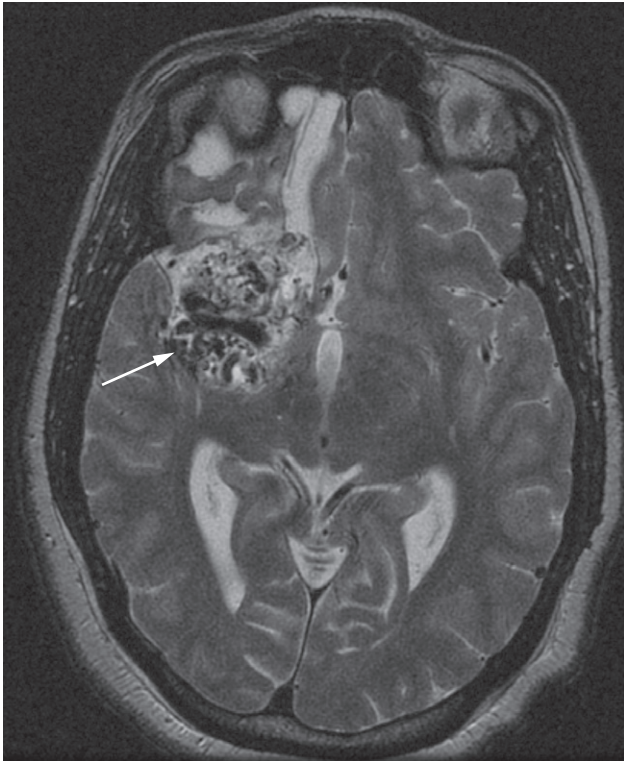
MRI of brain showing an arteriovenous malformation (arrow) in the right cerebral hemisphere. The fast-flowing blood in the malformation is responsible for the absence of signal (signal void). The image is a T2-weighted image, and is normal apart from the arteriovenous malformation and its consequences.
